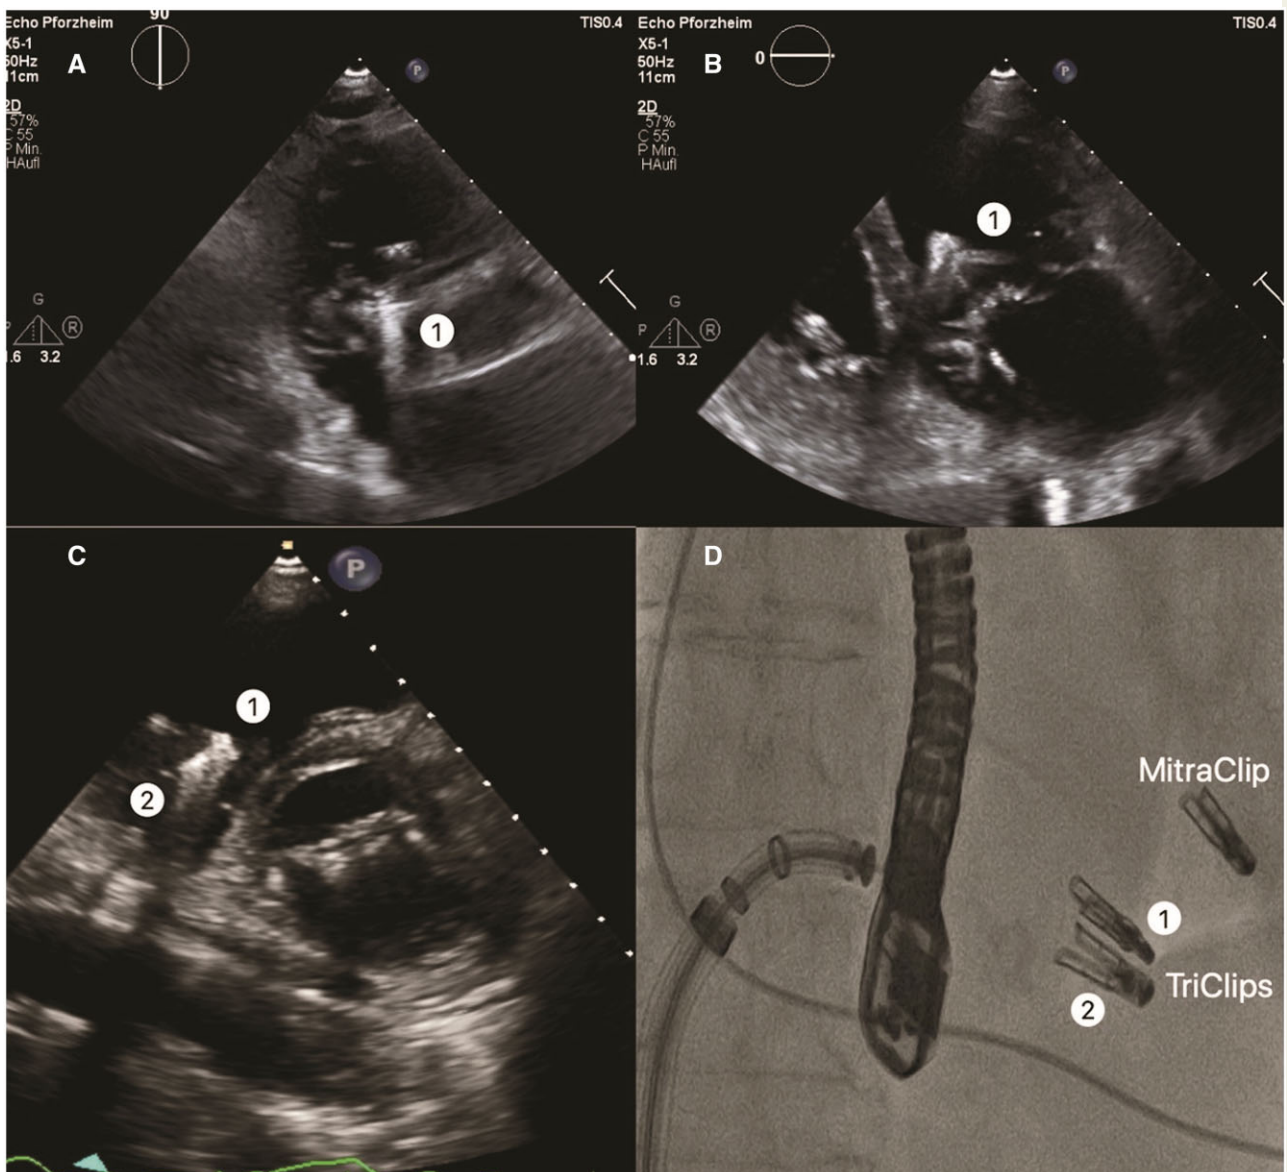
Periprocedural imaging of 1st clip during release and final position confirmation of both clips. (A) Transthoracic echocardiography parasternal short-axis view. (1) First TriClip between septal and anterior leaflet. (B) Transthoracic echocardiography parasternal long-axis right ventricular inflow view. (C) Transthoracic echocardiography parasternal short-axis view after implantation of two Clips. (2) Second TriClip between septal and posterior leaflets. (D) Fluoroscopic view of all clips, including MitraClip.
